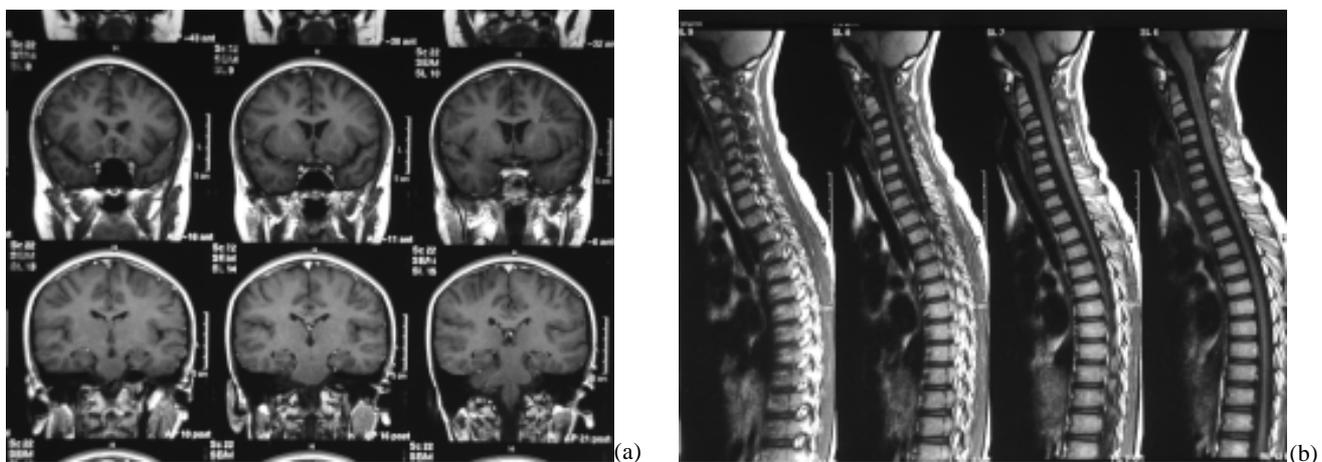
There were almost complete resolution of the enhancing cerebral and spinal nodules. Residual left frontalparietal and cervical intramedullary lesions were also showed in the MRI.
